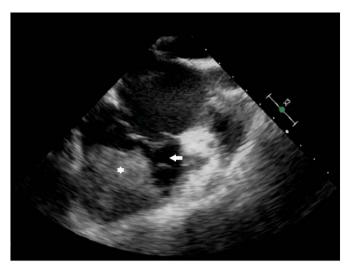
Echocardiogram showing the same mass (white star) and right ventricular cavity (white arrow)
